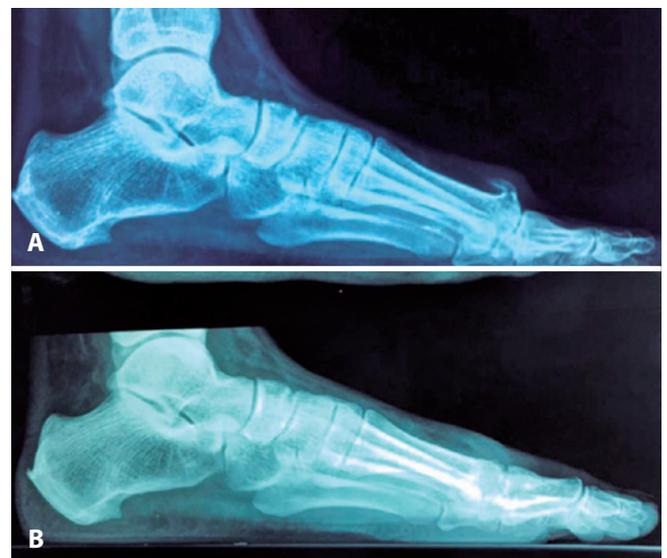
Profile radiographs before (A) and after (B) the procedure.
